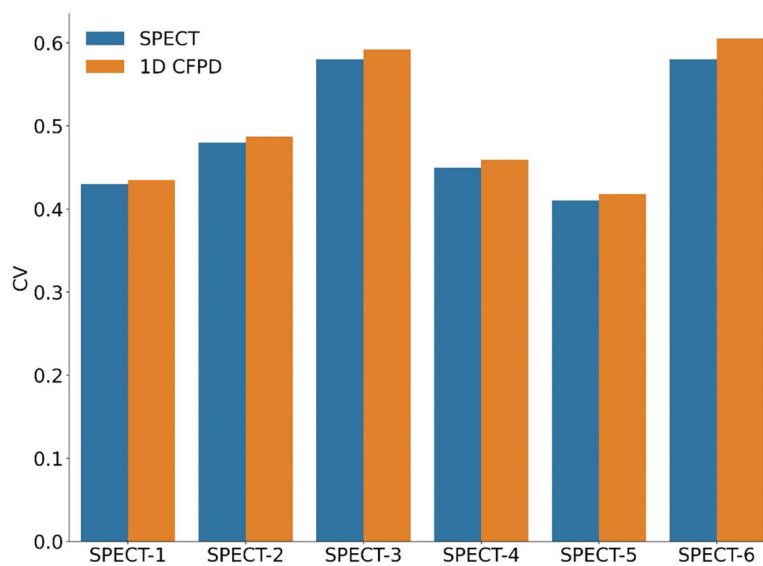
Coefficient of variation obtained from SPECT and 1D CFPD data for the 6 SPECT subjects. NRMSE < 0.05.
